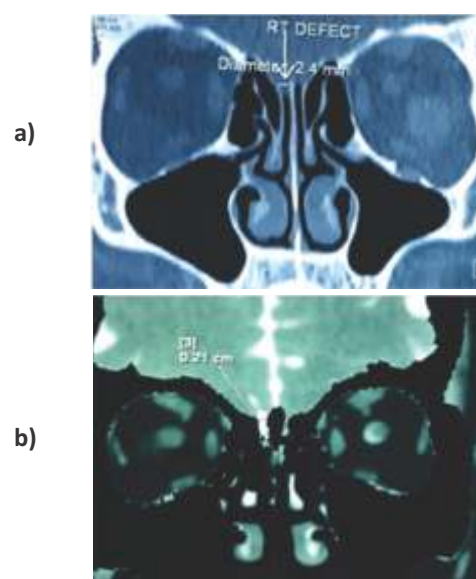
(a) Plain HRCT nose and paranasal sinuses coronal view showing defect in right cribriform plate and (b) CT cisternography showing defect in right cribriform plate
